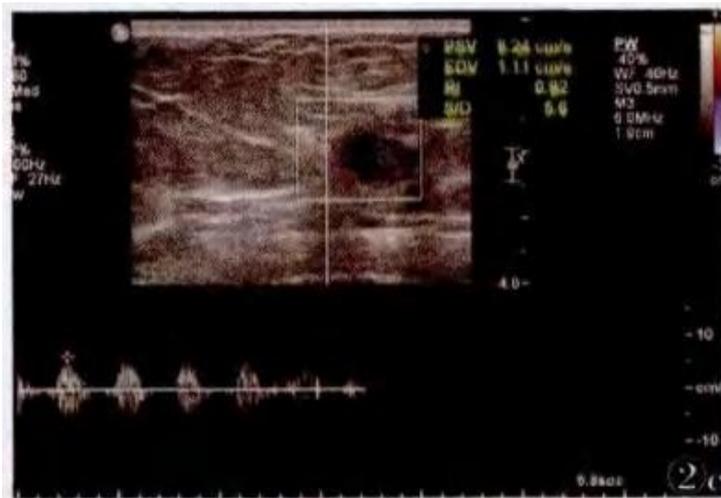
The sonogram demonstrates low internal echoes within the invasive ductal carcinoma, with spiculations and a high echogenic halo around the periphery.
